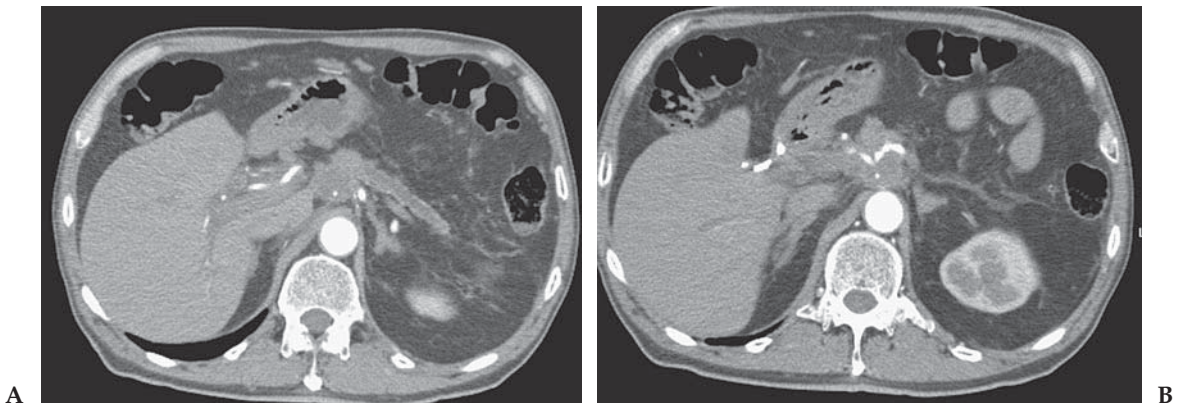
(A and B) Axial 2-mm images through the pancreas and celiac axis. There is a mass in the pancreatic head with marked atrophy of the pancreatic body and dilatation of the pancreatic duct. Tumor encasement of the celiac branches is shown. (Courtesy of Dr. Stanley Laucks, Alpha Advanced CT, York, PA.)
